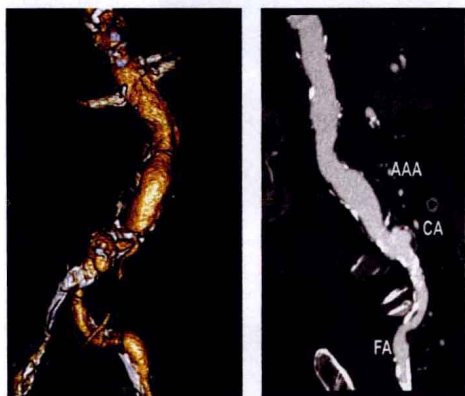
The volume-rendered image (left) of this aorta does not adequately reveal diffuse aneurysmal involvement. A curved multiplanar reconstruction (right) of this tortuous area enables electronic linearization of the aorta perpendicular to the flow of blood and provides a more reliable assessment of abdominal aneurysm length. (Reprinted from Goldman C, Sanz J. CT Angiography of the abdominal aorta and its branches with protocols. In: Mukerjee D, Rajagopalan S, eds. *CT and MRI angiography of the peripheral circulation: practical approach with clinical protocols*. London, UK: Informa Health Care, 2007:117, with permission.)
